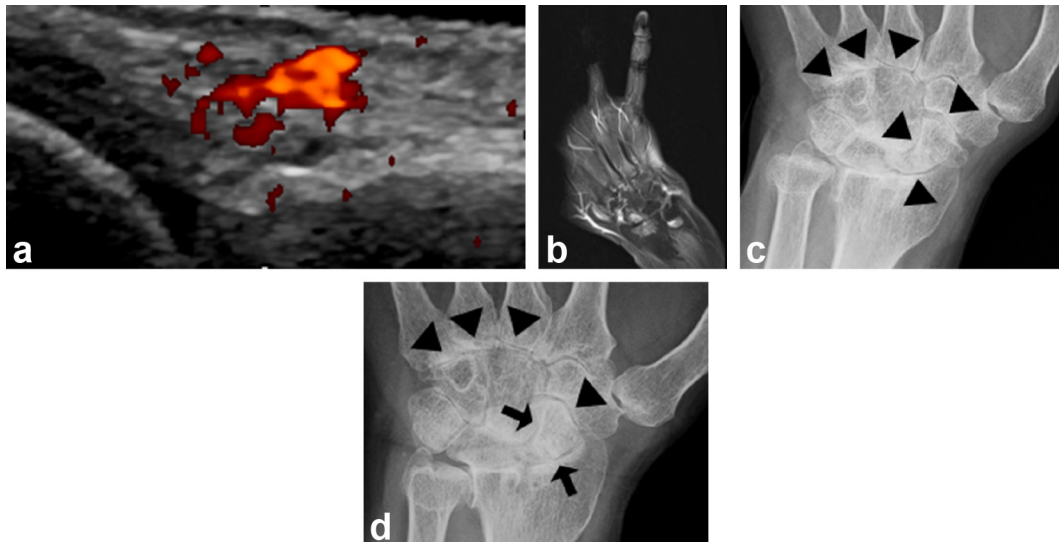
Ultrasonography, MRI and XR of a 60-year-old female suffering from RA with structural damage progression: (a) power Doppler ultrasonography image at baseline showing synovitis in the metacarpophalangeal joint of the right index finger. (b) Post-contrast fat-suppressed  $T_1$ -weighted image of the left hand at baseline showing synovitis in the radioulnar joint. Bone marrow edema was seen in the scaphoid bone and distal radius. (c) Baseline conventional radiograph of the left hand showing JSN in the third to fifth CM, SC, RS, and ST joints (arrow heads). (d) Conventional radiograph at 1 year follow-up showing stable third to fifth CM and ST joints (arrow heads). JSN progression in SC and RS joints (thin arrows) is demonstrated. CM, carpometacarpal; JSN, joint space narrowing; RA, rheumatoid arthritis; RS, radius-scaphoid; SC, scaphoid-capitates; ST, scaphoid-trapezium.
